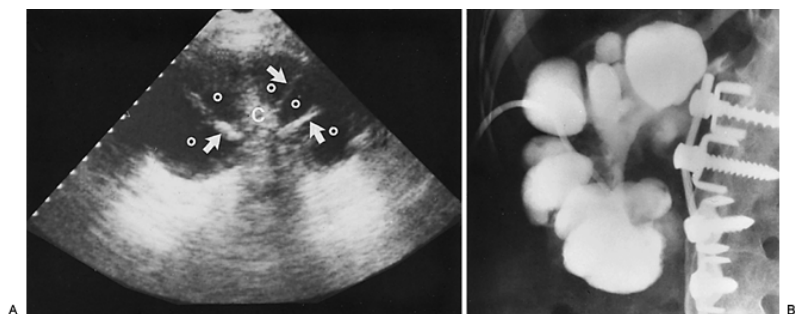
Pyonephrosis. A: Ultrasound. Longitudinal scan of the right kidney demonstrates echogenic central collecting complex (C) with radiating echogenic septae (arrows) and thinned hypoechoic parenchyma. Multiple dilated calyces (o) with diffuse low-level echoes are seen. B: Antegrade pyelogram performed through a percutaneous nephrostomy catheter correlates well with the ultrasound image. Dilated pus-filled calyces are demonstrated. The renal pelvis is obliterated by chronic scarring and stone disease. The kidney did not regain function.
